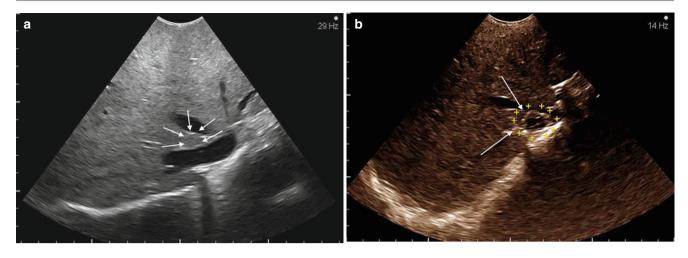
Contrast-enhanced ultrasound. (a) IOUS is unable to detect this isoechoic lesion. The lesion is marked by the *white arrows*. (b) Following injection of contrast medium, the liver metastasis appears (*white arrows* and *yellow* +). This particular lesion had disappeared on
